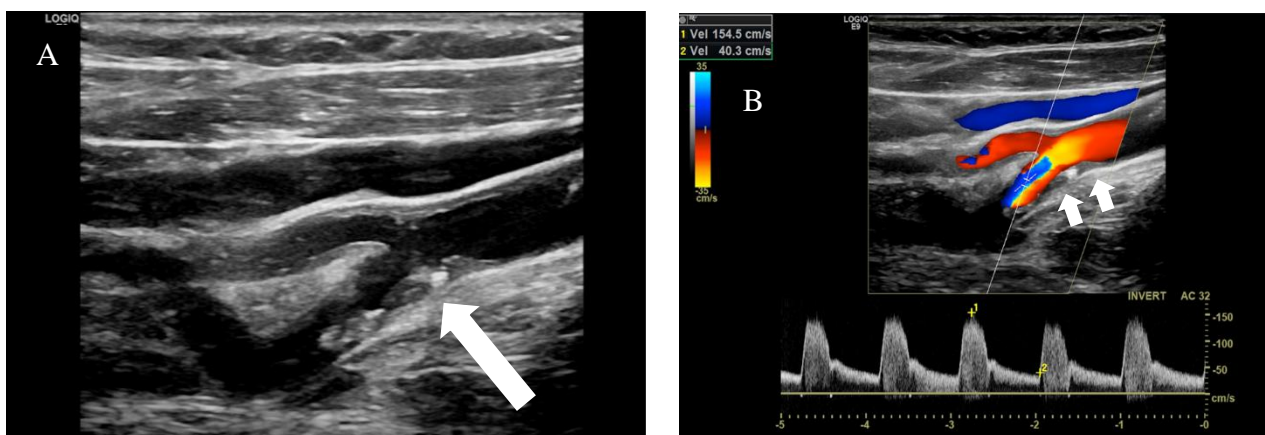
Extracranial Sonography of the Internal Carotid Artery.
